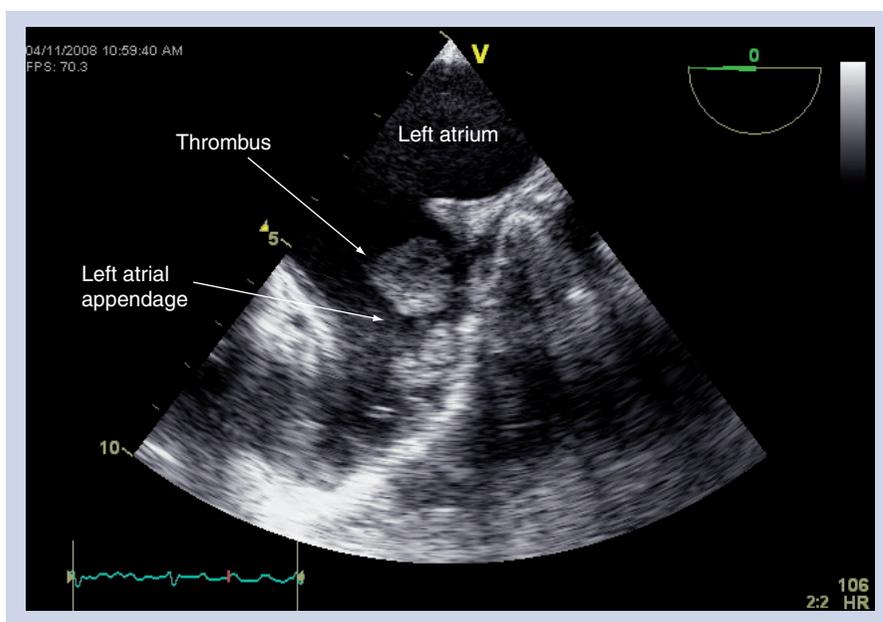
Left atrial appendage clot seen on transesophageal echocardiogram.
